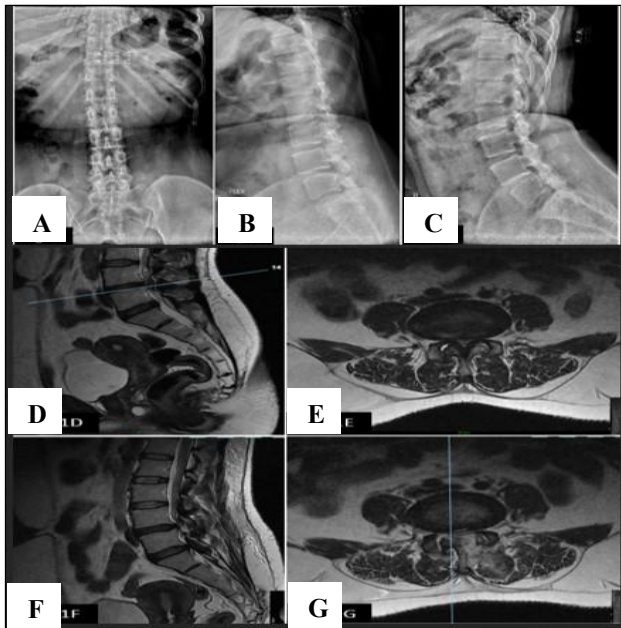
Case example 1: a 48-year-old female with a one-year history of left greater than right leg radiating pain. (A-C) Anteroposterior (AP), lateral in flexion, and lateral in extension radiographs; (D and E) sagittal and axial T2-weighted MRI images demonstrating severe neural compression, Schizas grade; (D, F and G) postoperative MRI images showing adequate decompression.
